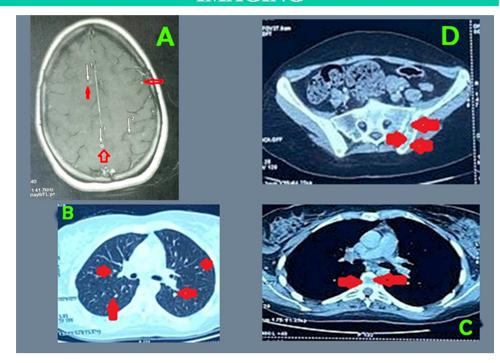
A. The brain MRI revealed multiple intra-axial supratentorial infra-centimetric lesions; B. An injected chest CT scan showed symmetrical micronodular opacities in both lungs resembling millet seeds; C. A CT scan of the thorax
